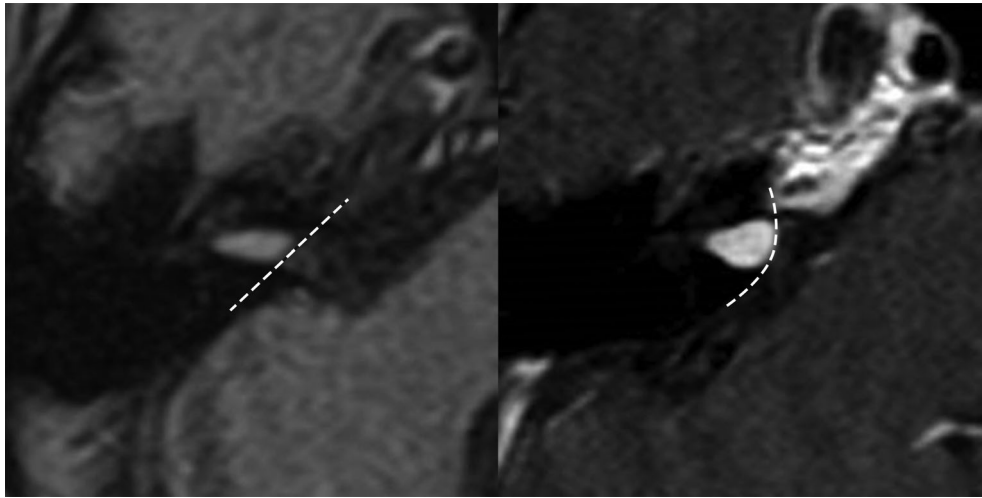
Preoperative MRI of intracanalicular meningiomas (axial T₁-weighted gadolinium-enhanced image). The dashed line outlines the medial border of the tumor. Linear medial border (left) and convex medial border (right). MRI = magnetic resonance imaging; T₁= longitudinal relaxation time.
